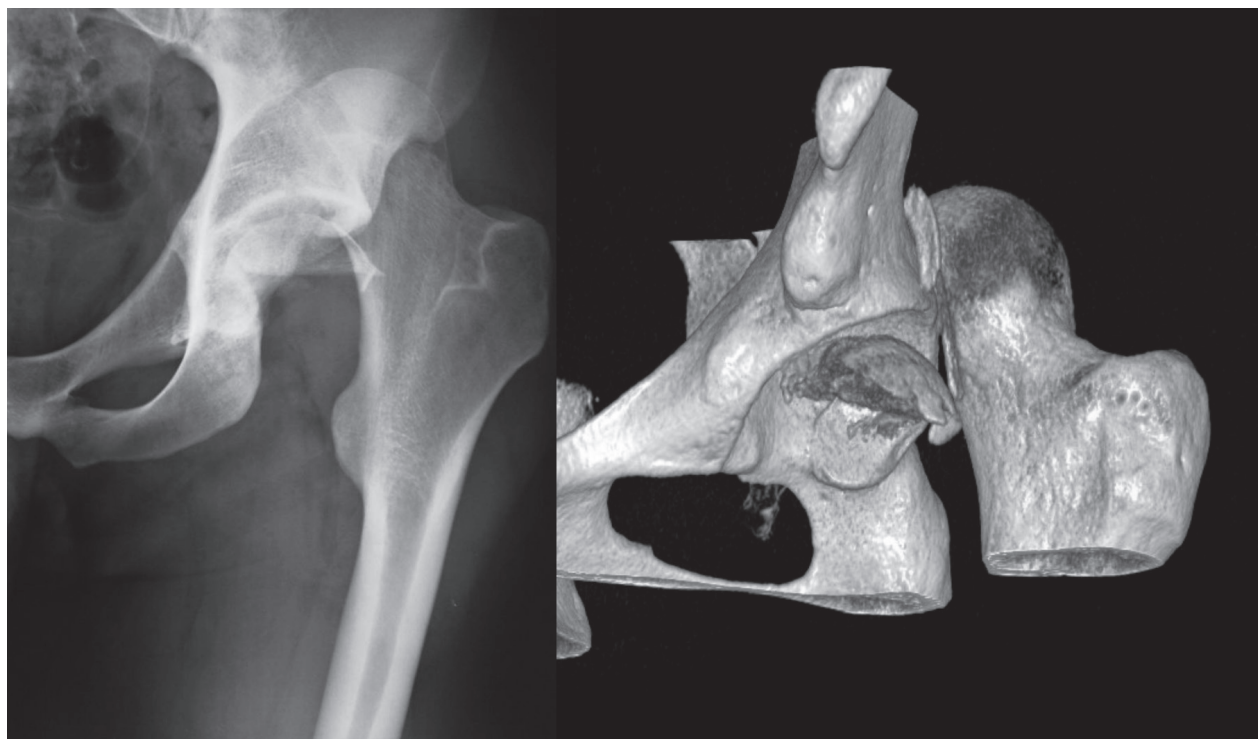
Preoperative Pelvic X-Ray and 3D CT scan showing posterior hip dislocation and large intrarticular fragment of the femoral head
